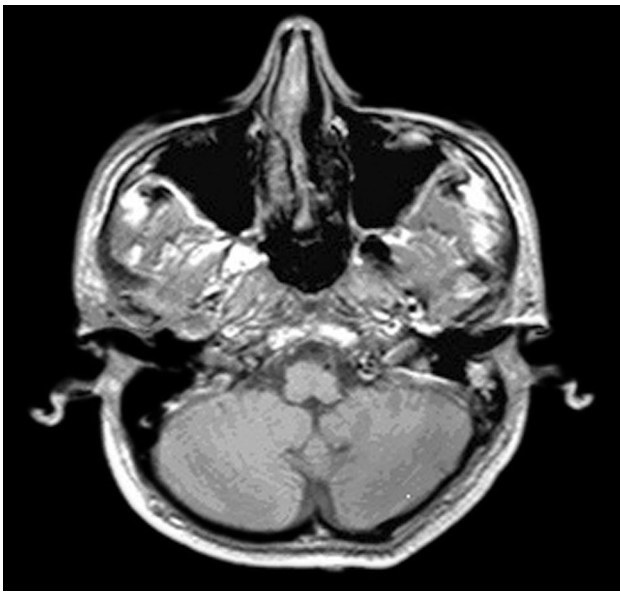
Postoperative magnetic resonance imaging one year. No mass reported.
